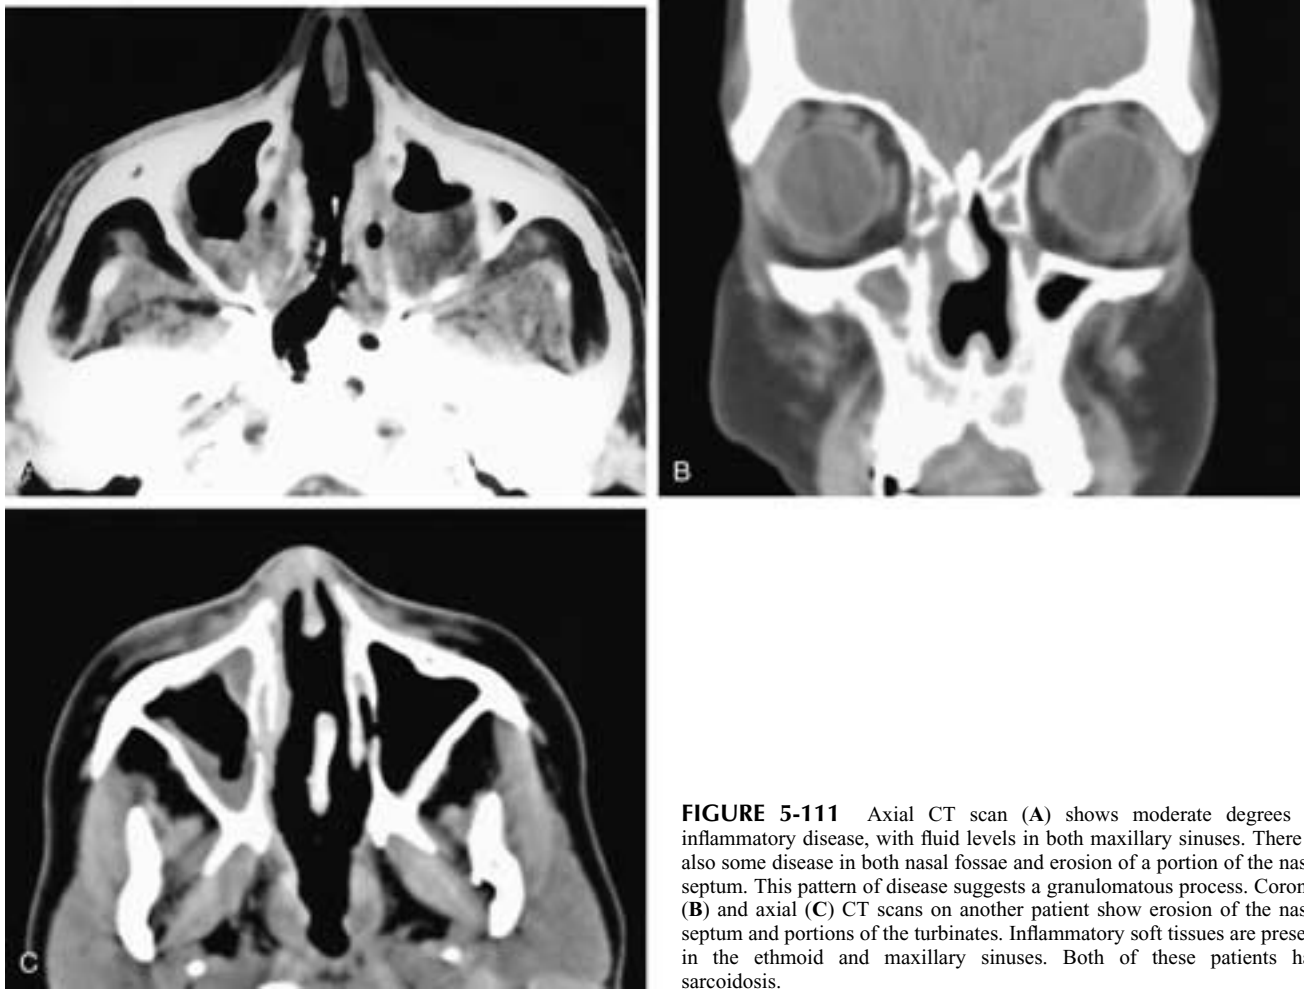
Axial CT scan (A) shows moderate degrees of inflammatory disease, with fluid levels in both maxillary sinuses. There is also some disease in both nasal fossae and erosion of a portion of the nasal septum. This pattern of disease suggests a granulomatous process. Coronal (B) and axial (C) CT scans on another patient show erosion of the nasal septum and portions of the turbinates. Inflammatory soft tissues are present in the ethmoid and maxillary sinuses. Both of these patients had sarcoidosis.
